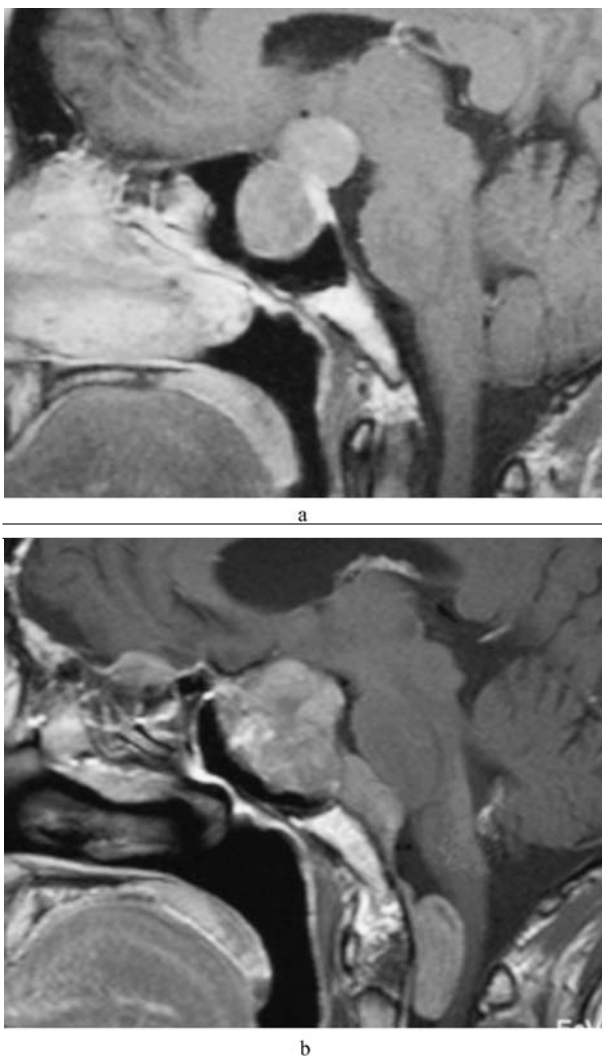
a. Pretreatment MRI demonstrates a pituitary tumor with suprasellar extension. There was weak heterogeneous enhancement after contrast medium administration. The MRI finding closely resembled those of pituitary adenoma. b. Preoperative MRI obtained at our hospital showed a huge, invasive pituitary tumor extending to the sphenoid sinus and frontal base. There was a disseminated cervical mass in the C1 region.
